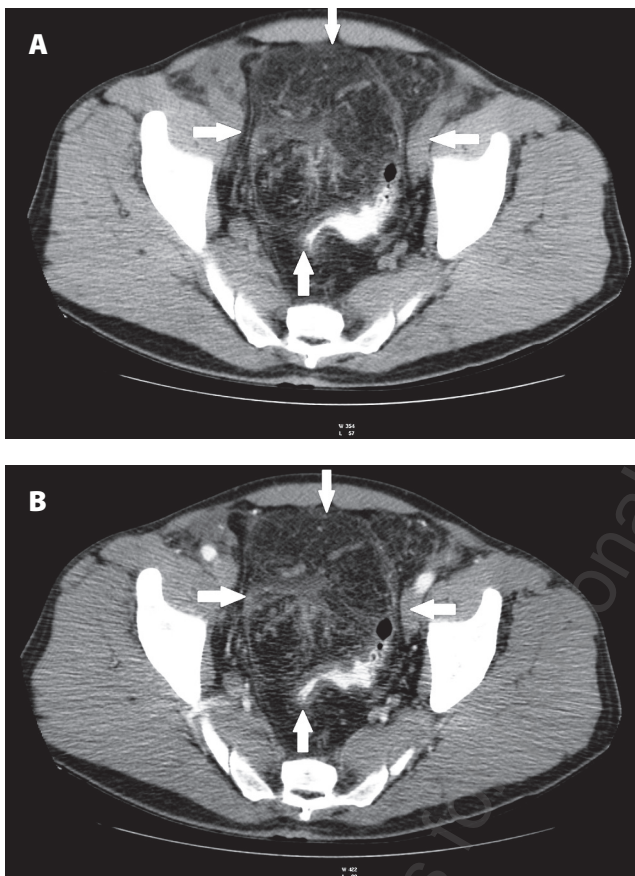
Pelvis minor (A): CT – unenhanced axial scan. (B): CT + CM – arterial phase, axial scan. Pathological mass of adipose tissue predominantly moving sigmoid colon to the left and exerting pressure on it
